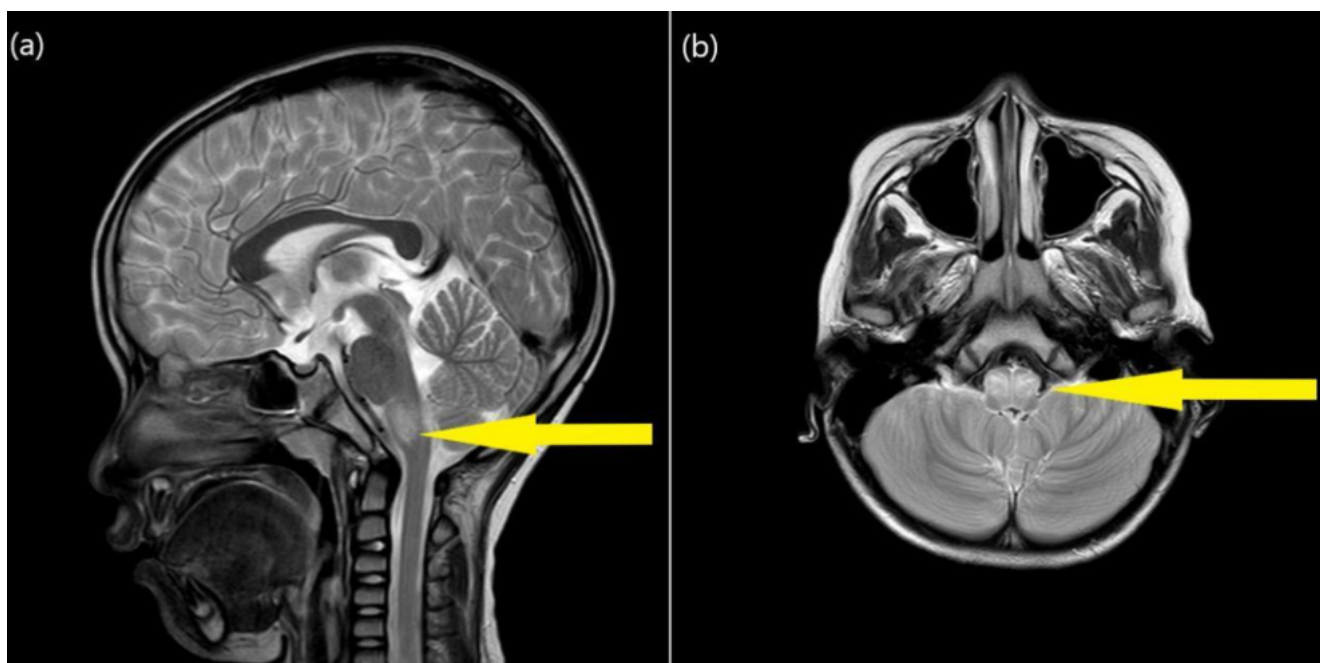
Magnetic resonance imaging brain showing fluffy T2 hyper-intense signals over the brainstem. (a) Sagittal plane (b) Axial plane.
